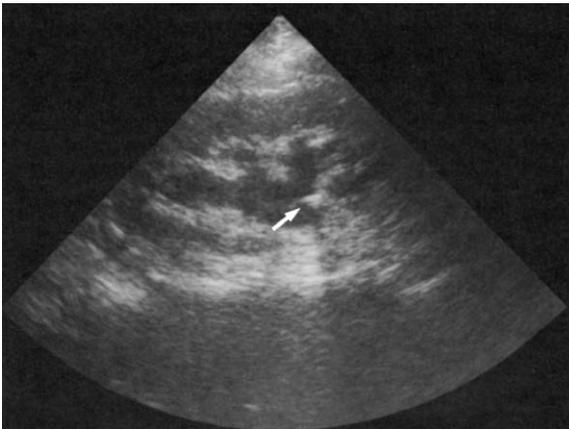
Hydronephrosis. Longitudinal view of the kidney reveals dilated renal collecting system and pelvis. Note the calculus in the renal pelvis (*arrow*). (From Chang TS, Lepanto L. Ultrasonography in the emergency setting. *Emerg Med Clin N Am* 1992;10:8; with permission.)
